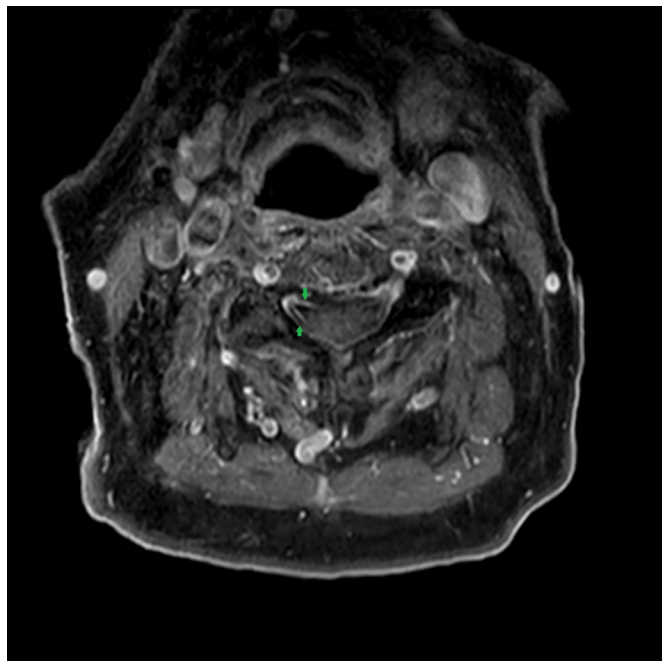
MRI image of gadolinium contrast enhancement on the right dorsal and ventral C5 nerve rootlets (green arrow).
